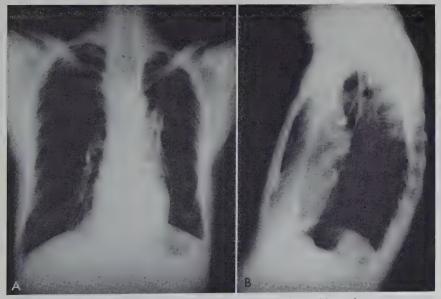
(Case I). Late postoperative anteroposterior and lateral roentgenograms of the chest indicate good healing and preservation of function of the lobe remaining in the left side of the chest.
